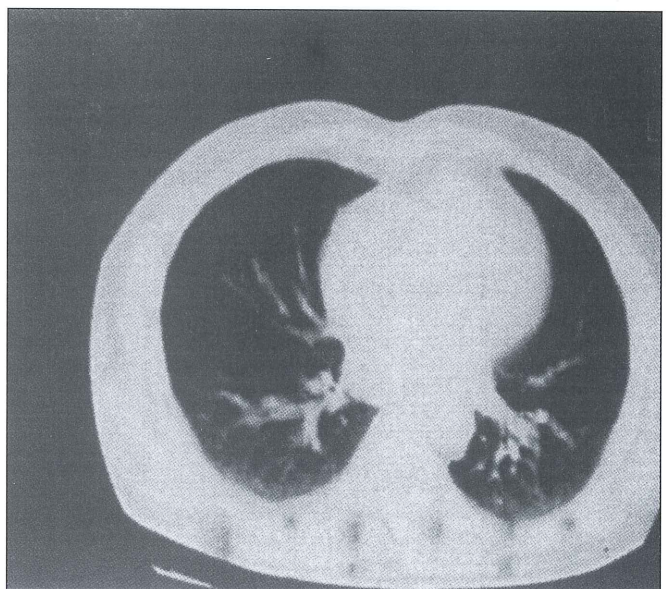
The computed tomography scan after seven months of therapy
